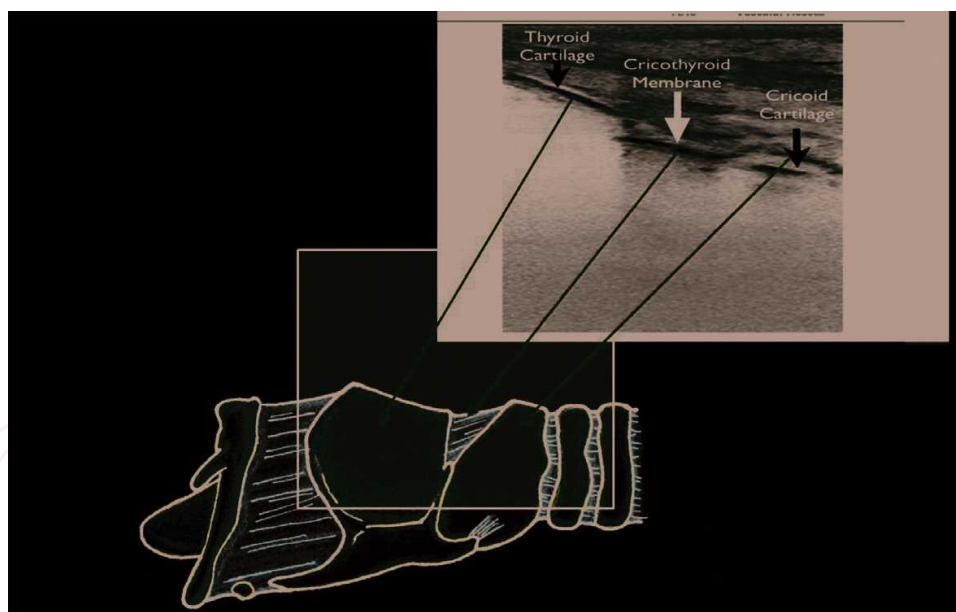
Ultrasound images of larynx and trachea rings.
